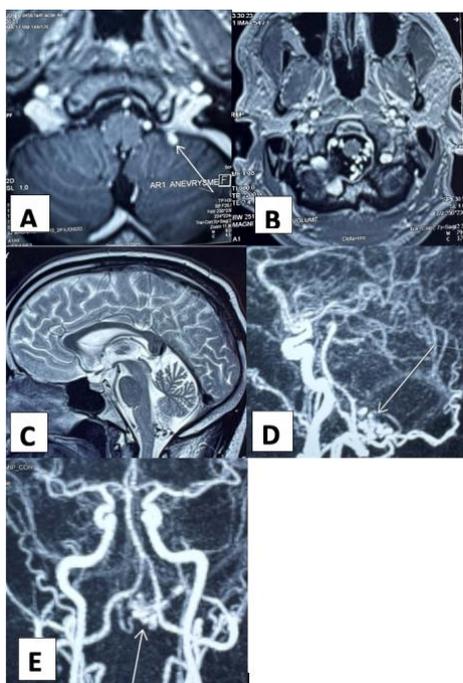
Brain MRI, axial T2 flair (A), sagittal T2 (B), axial T2 diffusion (C), cerebral MRI with MIP reconstruction in sagittal (D), frontal (E) sections: suspected AVF of the craniocervical junction with a single draining vein oriented superiorly and laterally. Note presence of a venous aneurysm.
